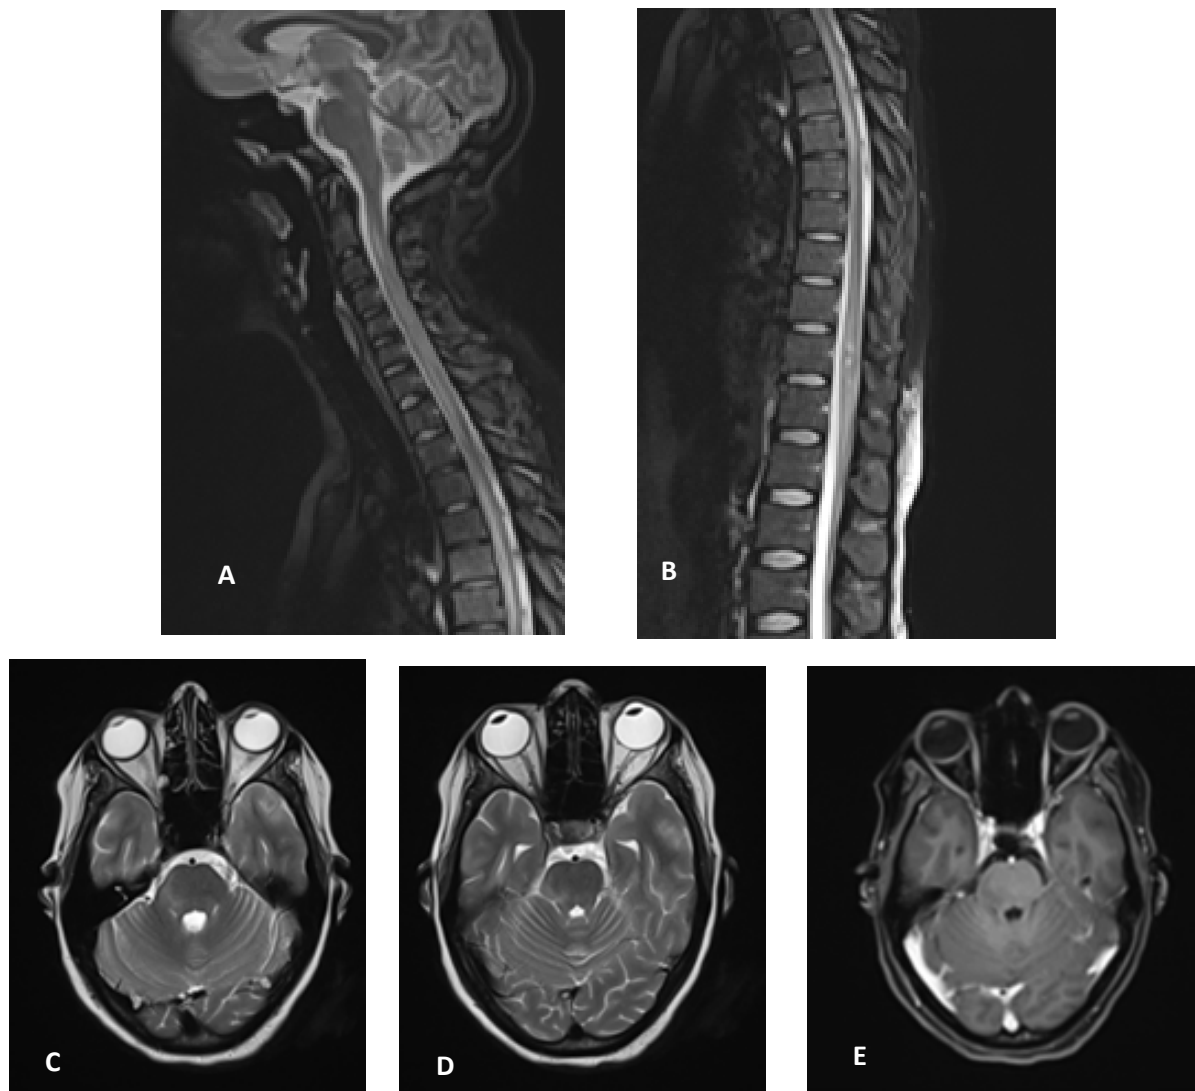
MRI of the cervical and thoracic spine (A and B, STIR sagittal cervical and thoracic, C and D axial T2W, E post contrast axial) showed presence of longitudinally extensive lesions spanning from C2 to T1 and D3 to D7, characterized by hyperintensity on T2-weighted images and hypo-intensity on T1-weighted images without atrophy of the cord. The MRI of the Brain revealed subtle hyperintensities on T2-weighted images in the brainstem, especially in the pons on right side. There was no gadolinium enhancement in the area.
